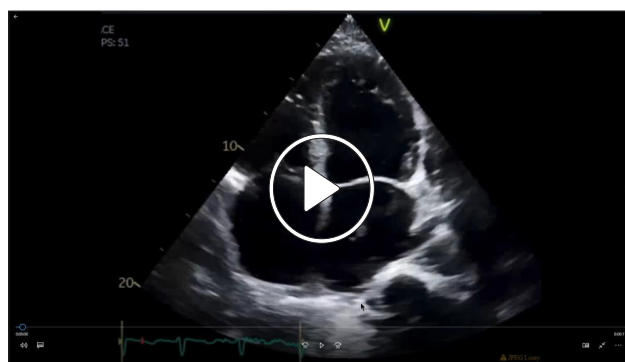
(A) Echocardiogram shows a large thrombus extending from the right atrium through the interatrial septum into the left atrium. (B) Three-dimensional echocardiogram show a large thrombus extending from the right atrium through the interatrial septum into the left atrium and left ventricle.
